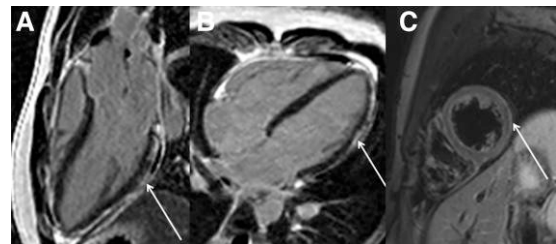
(A and B) Phase sensitive inversion recovery cardiac magnetic resonance images performed 3 days after 2nd dose of Pfizer–BioNTech vaccine (BNT162b2). Sub-epicardial late gadolinium enhancement (hyperintense signal arrows) is observed in the basal, mid, and apical lateral wall in a pattern consistent with myocarditis. (C) T2-weighted fat saturated image taken at a mid-left ventricular level showing focal areas of corresponding sub-epicardial high signal intensity indicative of myocardial oedema.
